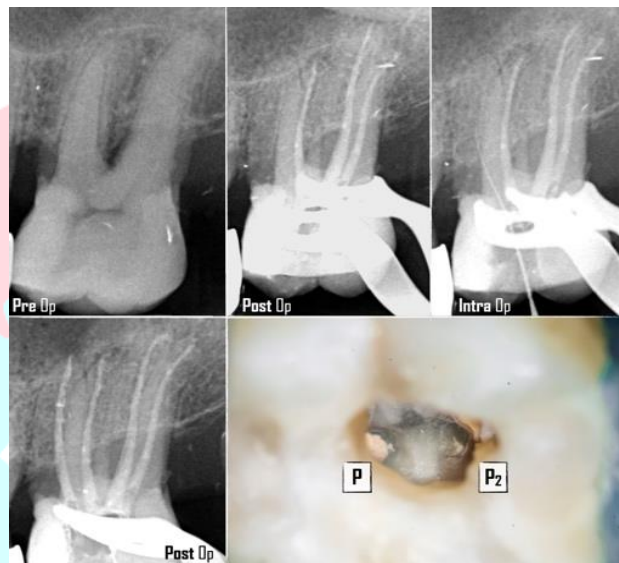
Endodontic treatment of upper molar with two palatal canals – preoperative, intraoperative, postoperative x-ray and clinical view
